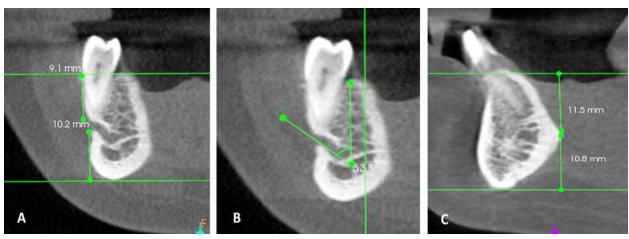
Mandibular parameters on CBCT, A: Position of mental foramen, B: Angle of mental foramen opening, C: Position of genial tubercles.
